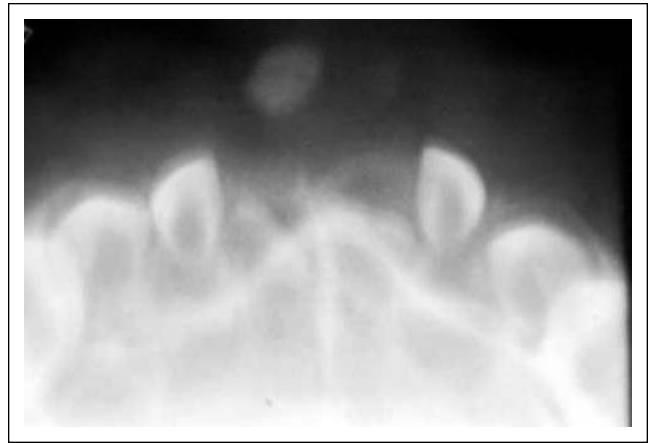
An occlusal radiograph that exhibits soft tissue enlargement with focal opacity that is the same density as dentin and cementum.
